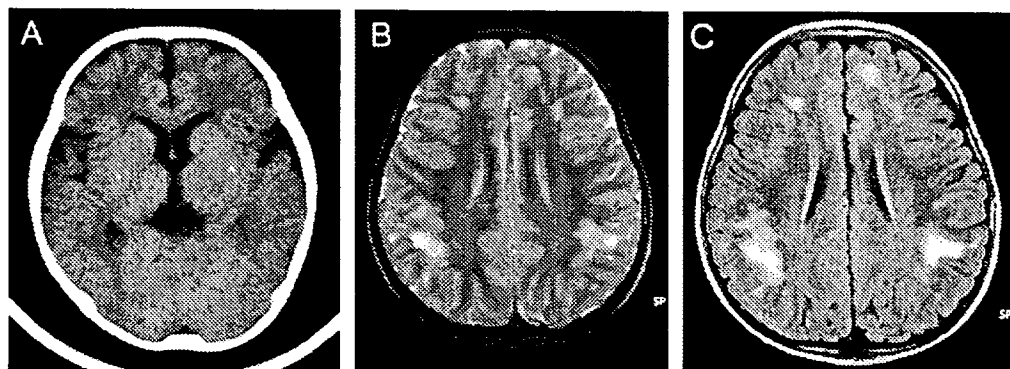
Neuroimaging. (A) Brain CT at age 9 months. (B and C) Magnetic resonance imaging at age 4 years (B, T2-weighted image; C, fluid-attenuated inversion recovery image). Multiple high-signal lesions with vague contours distribute in the subcortical, and adjacent deep white matter bilaterally, at the frontal, temporal and parietal areas. No cortical lesion has been identified on neuroimaging.
